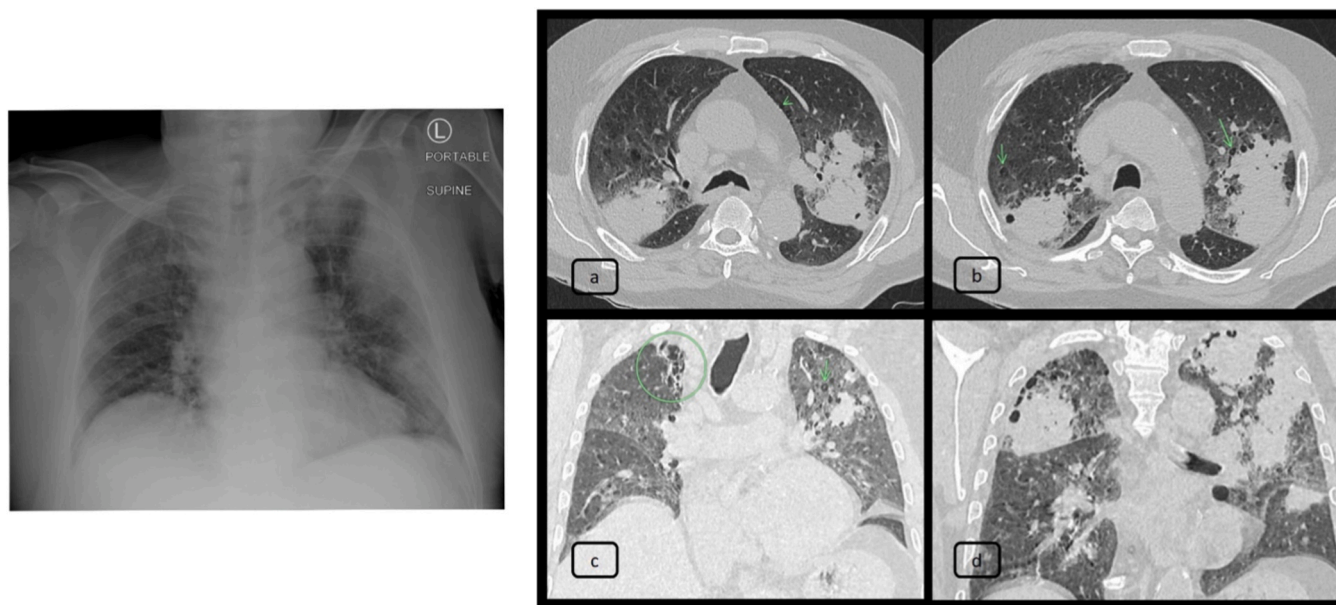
Chest X-ray and high resolution computed tomography (HRCT) of the chest: Chest X-ray (left): multifocal confluent consolidations of the left upper and middle zones and faint consolidation in the right upper zone. HRCT of the chest (right): axial and coronal images of the chest showing bilateral multifocal confluent dense consolidations, generalized ground-glass density of the lung parenchyma on background of mild emphysema (images a, b, and c), and focal area of bronchiectasis at the right apex (image d).
